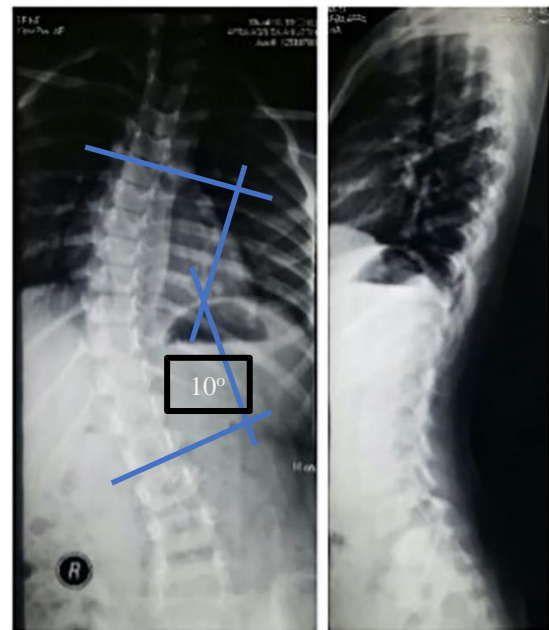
The thoracolumbar x-ray showed levoscoliotic alignment.
